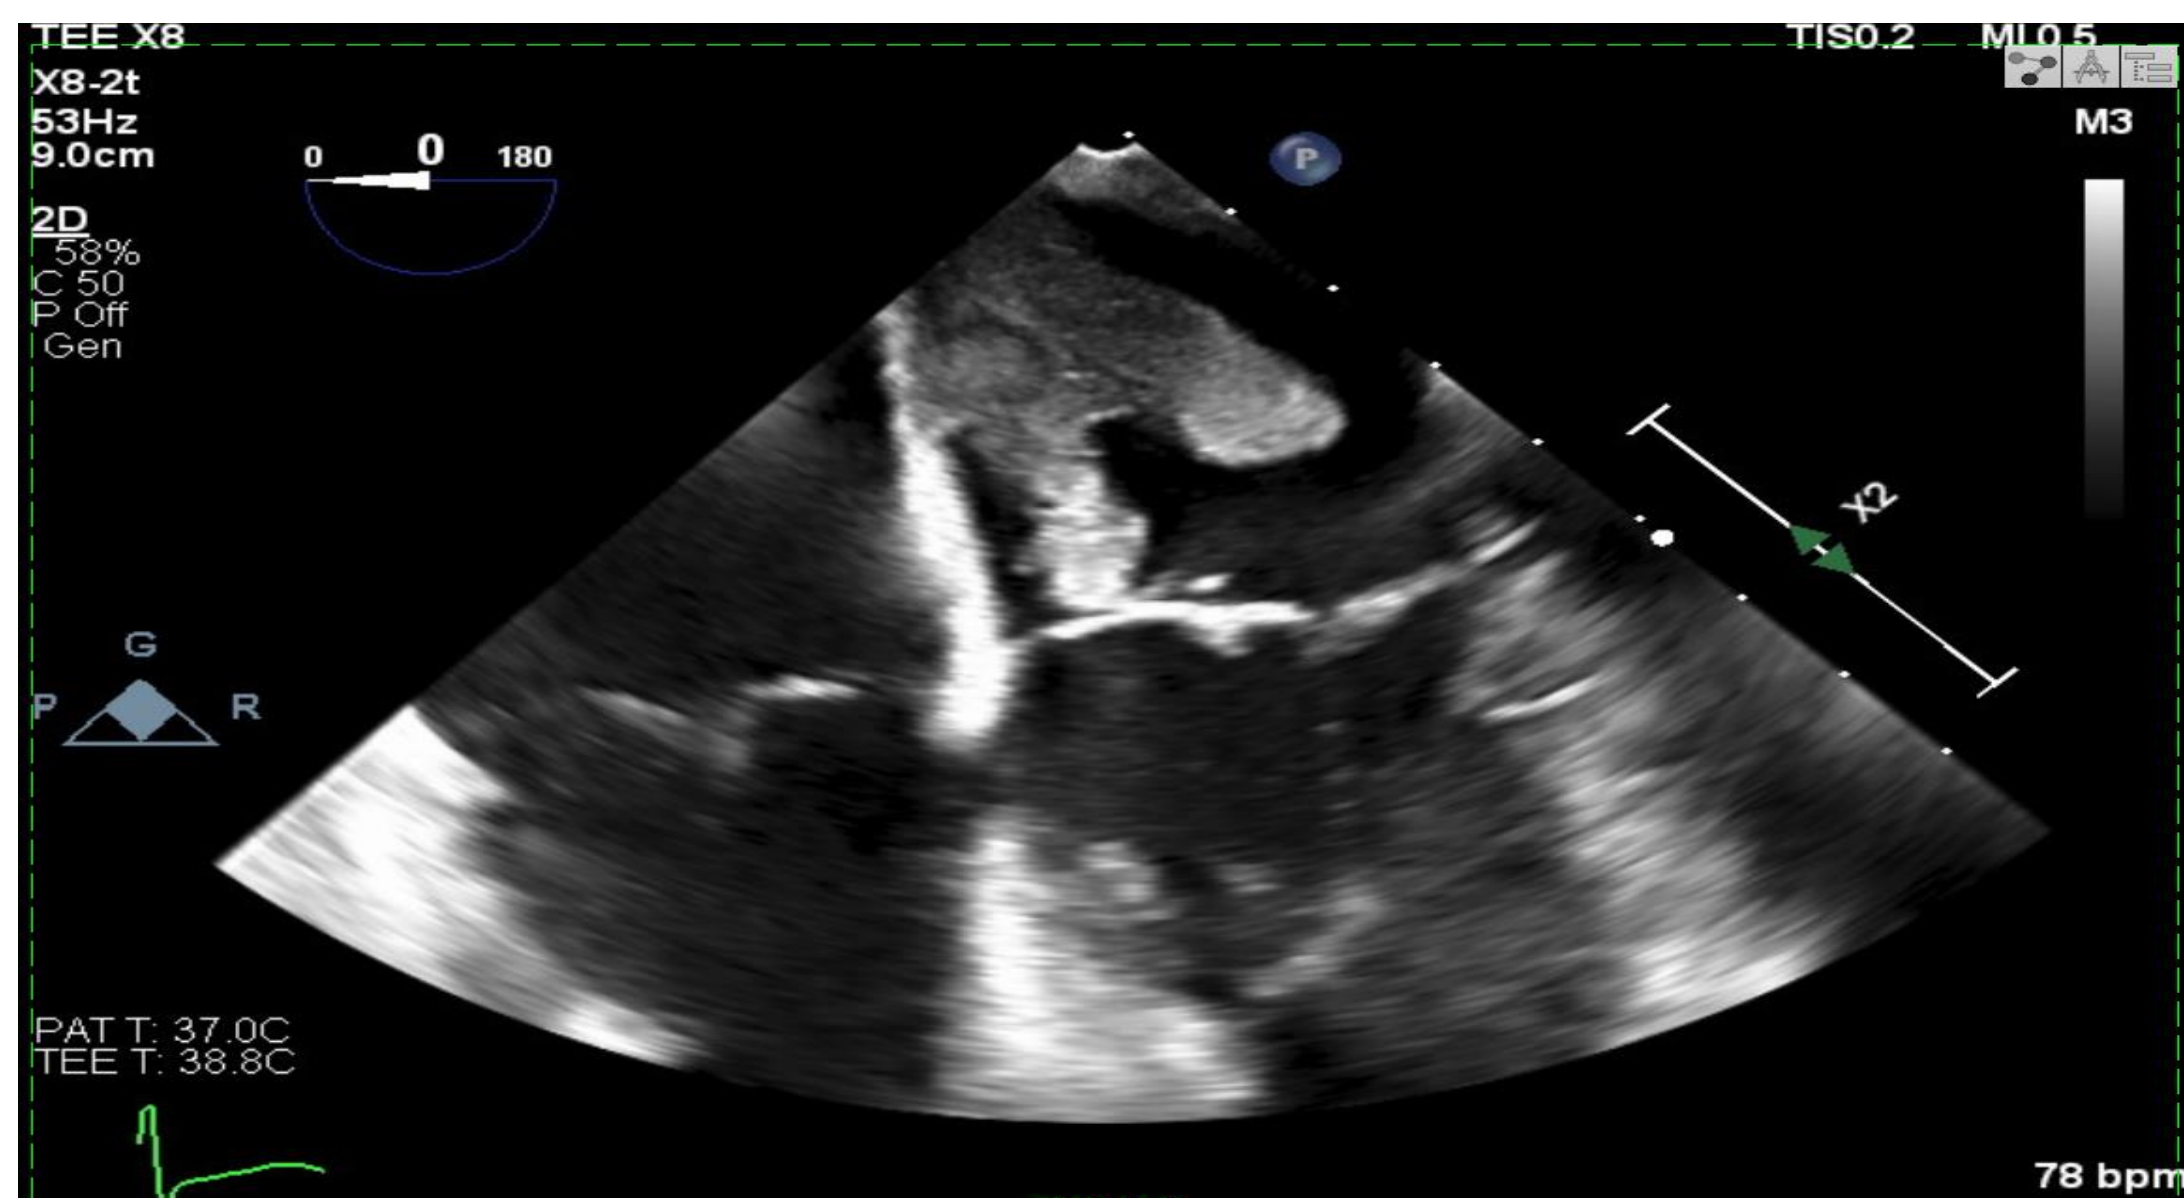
Transesophageal echocardiogram showing the bicuspid atrial valve
